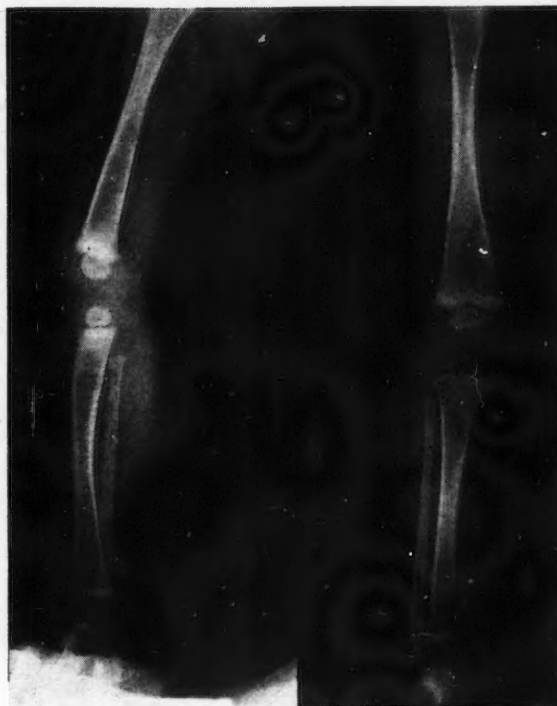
Radiograph of right leg at 8 months of age.
